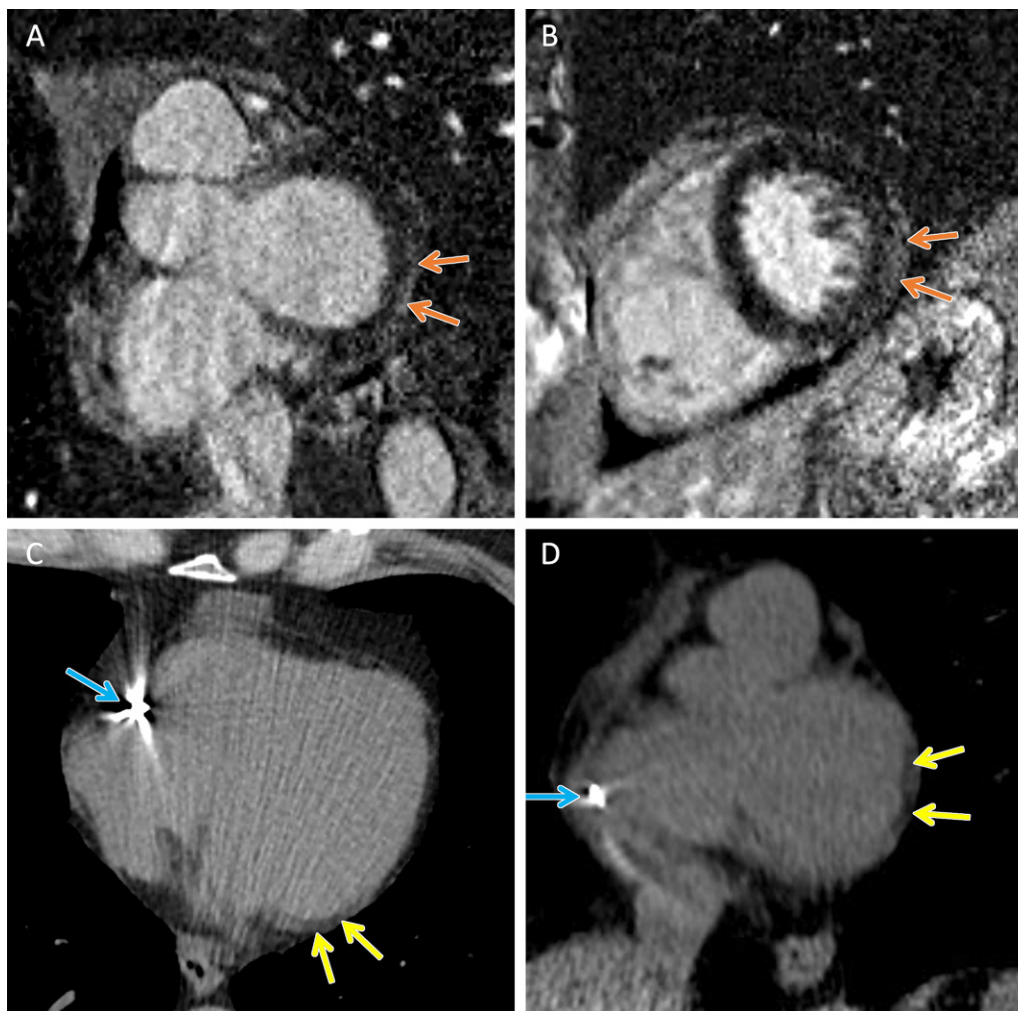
TMEM43* arrhythmogenic cardiomyopathy. Cardiac CT and MR images in a female patient between 50 and 59 years of age (exact age not provided due to potential reidentification risk) with a *TMEM43* variant of unknown significance (p.Glu142Gly) with premature ventricular beats at Holter monitoring. (A, B) Short-axis late gadolinium enhancement images at the (A) base and (B) midventricle demonstrate subepicardial late gadolinium enhancement involving the basal to mid inferolateral wall (orange arrows). (C) Axial and (D) short-axis noncontrast cardiac CT images demonstrate subepicardial fat along the lateral basal left ventricular wall (yellow arrows) and right ventricular implantable cardioverter defibrillator lead (blue arrows).
